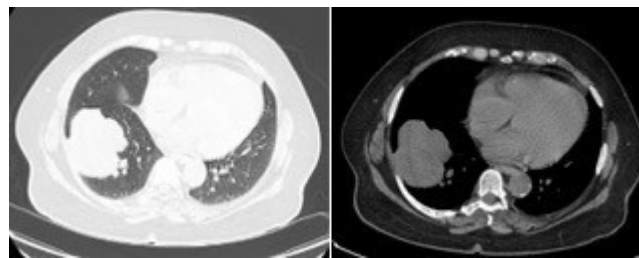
Computed tomography: (A) axial section, showing a mass-like lesion with heterogeneous density and irregular, popcorn-like margins, measuring 26 mm x 21 mm
